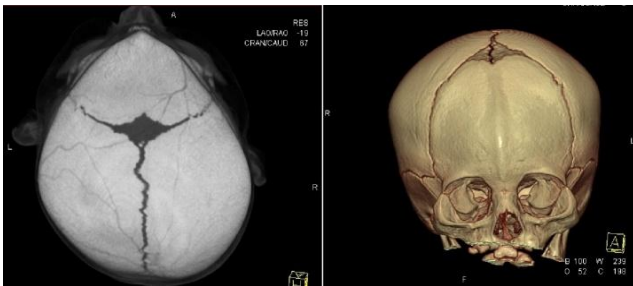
3D reconstructed CT scan. Note the metopic suture synostosis, seen as a mid-forehead ridge, hypotelorism, flattening of the frontal bones, anterior displacement of the coronal sutures, compensatory bulging of the parieto-occipital region and temporal narrowing
